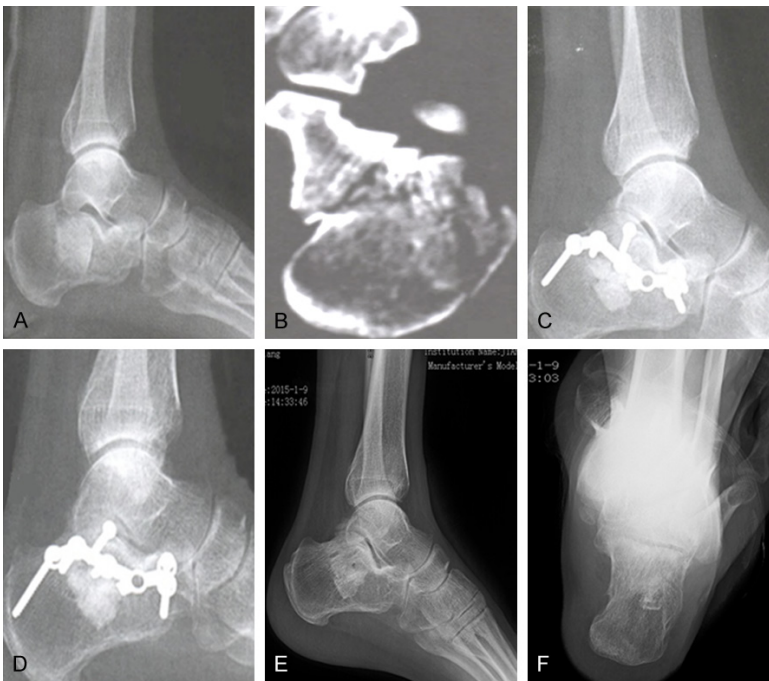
One case of intra-articular joint depression type calcaneus fractures treated via sinus tarsi approach with modified calcaneal plate (n=48 feet, 40 patients). A. Preoperative X-ray image of calcaneus. B. Preoperative CT film image of Sanders III fracture. C. Postoperative X-ray image of calcaneus (showed satisfied fixation). D. X-ray image after fracture healing (no significant loss of reduction). E, F. X-ray images after removal of internal fixation.
